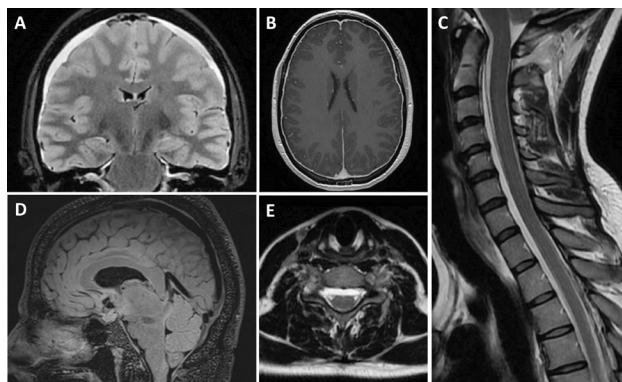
MR brain scan signs of SIH. (A) Coronal FLAIR sequence showing bilateral subdural collections. (B) Axial T1 post-contrast sequence showing generalised smooth dural enhancement. (C) Sagittal T2 of the cervical spine showing spinal longitudinal epidural collection. (D) Sagittal T2 SPACE sequence showing brain sagging and distension of venous sinuses. (E) Three-dimensional (3D) axial T2 CUBE (heavily T2-weighted 3D sequence) of the upper cervical spine in the same patient as image C showing ventral epidural collection. FLAIR, fluid-attenuated inversion recovery; SIH, spontaneous intracranial hypotension.
